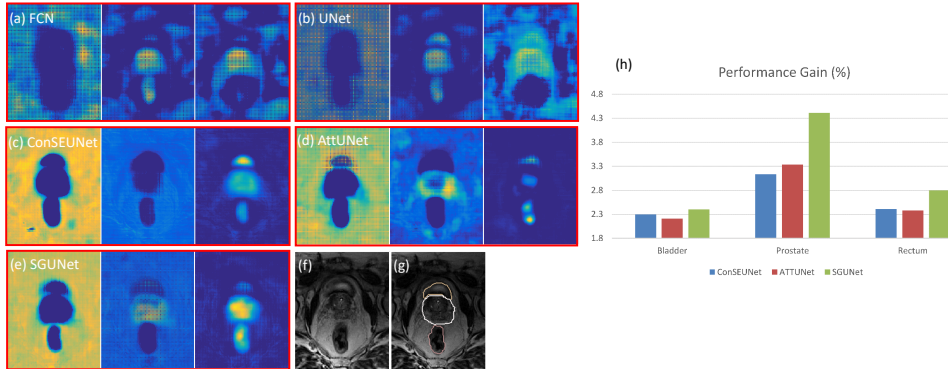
(a-e): Visualization of three typical learned feature maps of a certain layer by five different networks. (f) and (g) are the corresponding input MRI and the MRI overlaid by the ground-truth contours. (h) is the performance gain in terms of DSC with different strategies towards the UNet with *multi-scale deep supervision*.
